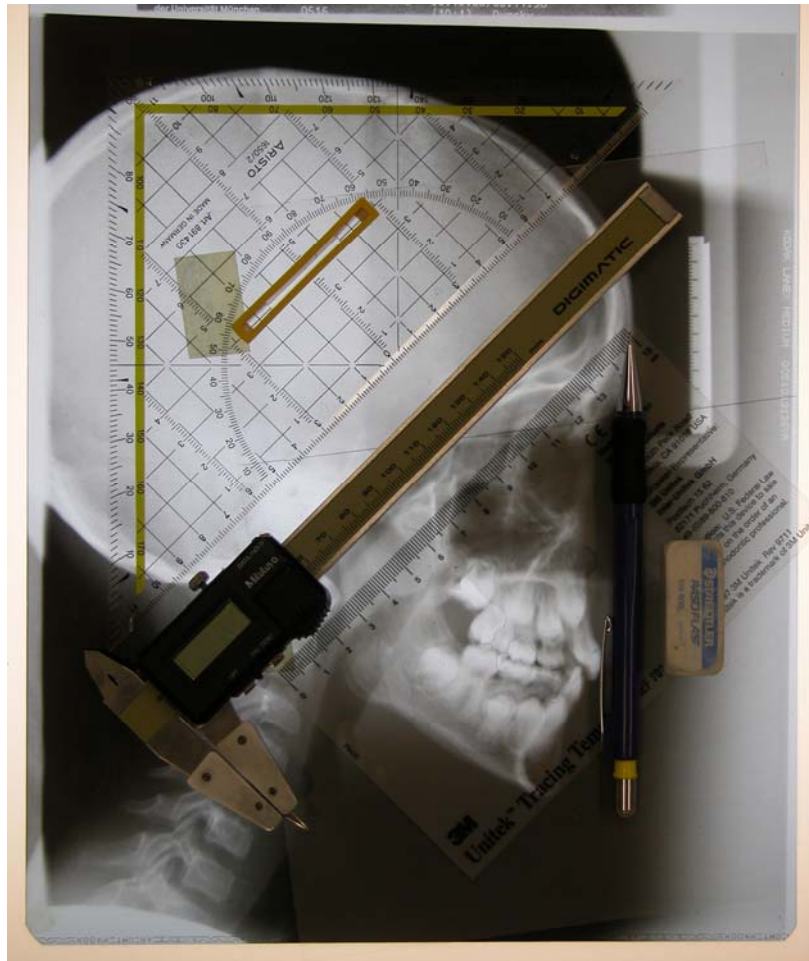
Lateral cephalometric radiograph, acetate paper, three angle ruler, digital calliper, Tracing-template 3M[®], pencil and rubber
